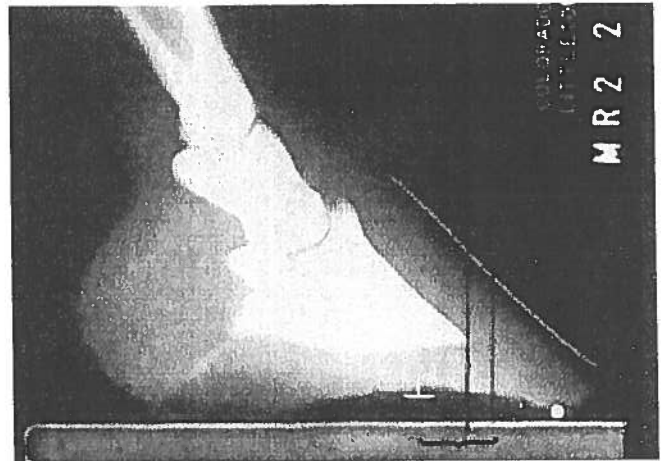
Radiograph showing the desired breakover distance.
